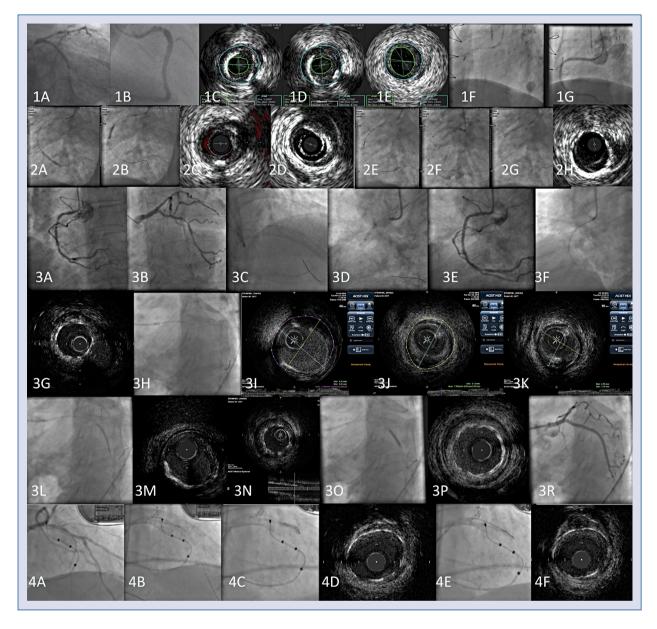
Intravascular ultrasound-guided percutaneous coronary intervention. 1A–G. Case 1; 2A–H. Case 2; 3A–R. Case 3; 4A–F. Case 4.
